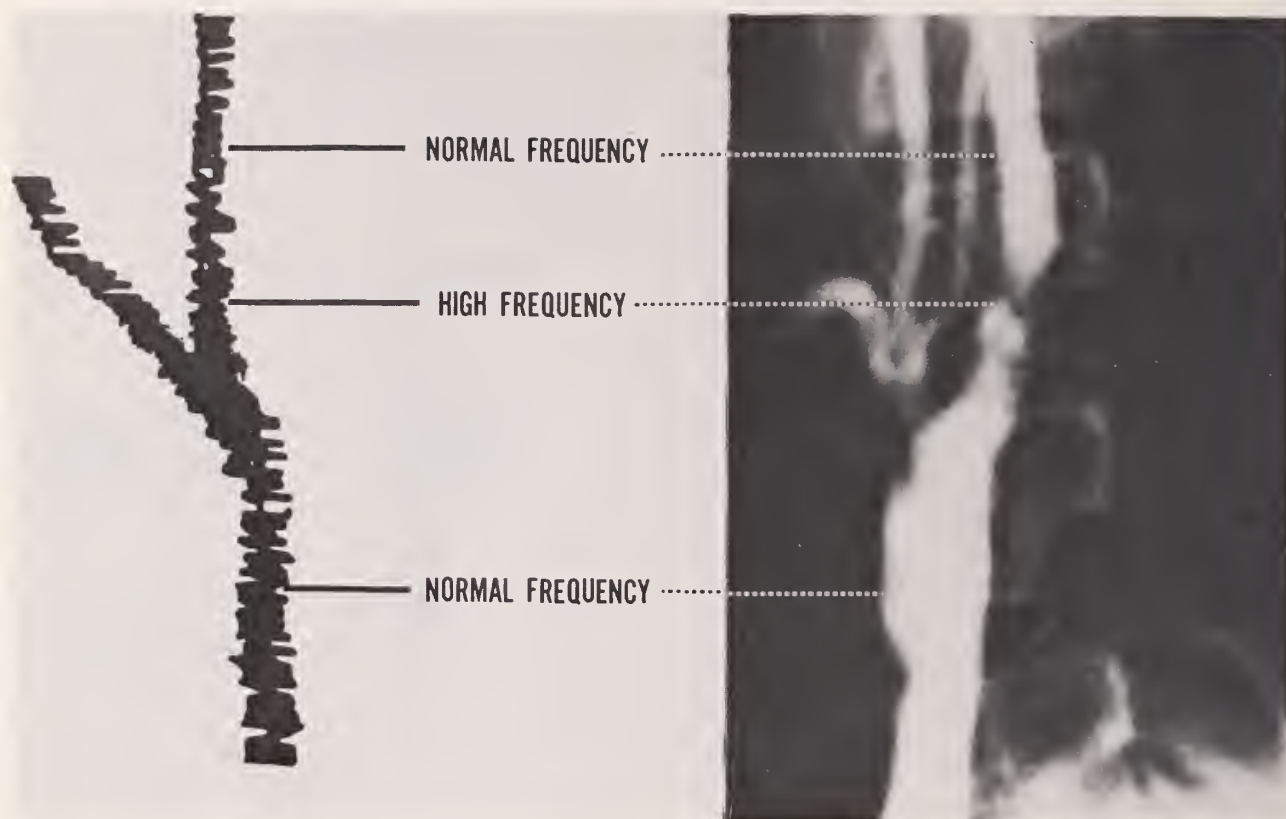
Dopscan image provides a guide for localization of high frequency Doppler signal associated with stenosis.
